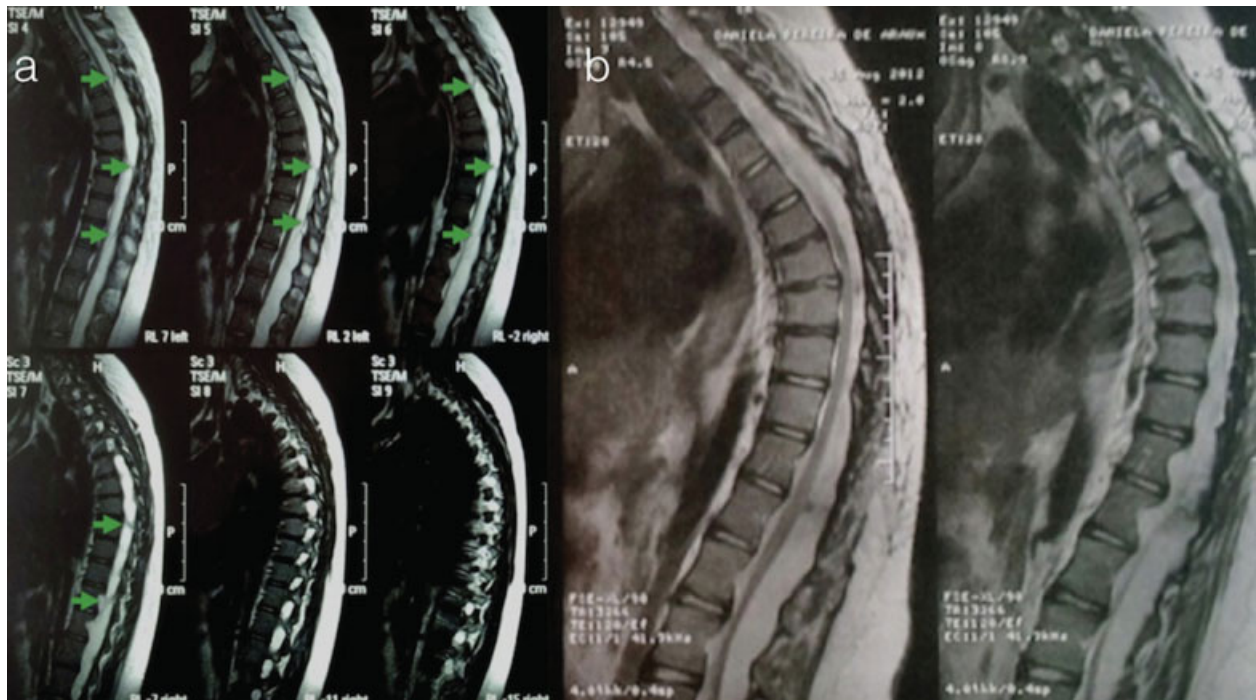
(a) Preoperative T2 sagittal MRI showing extradural cyst extending from T5 to T12 (green arrows). (b) Postoperative T1 sagittal MRI showing the resection of the posterior wall of the cyst.
